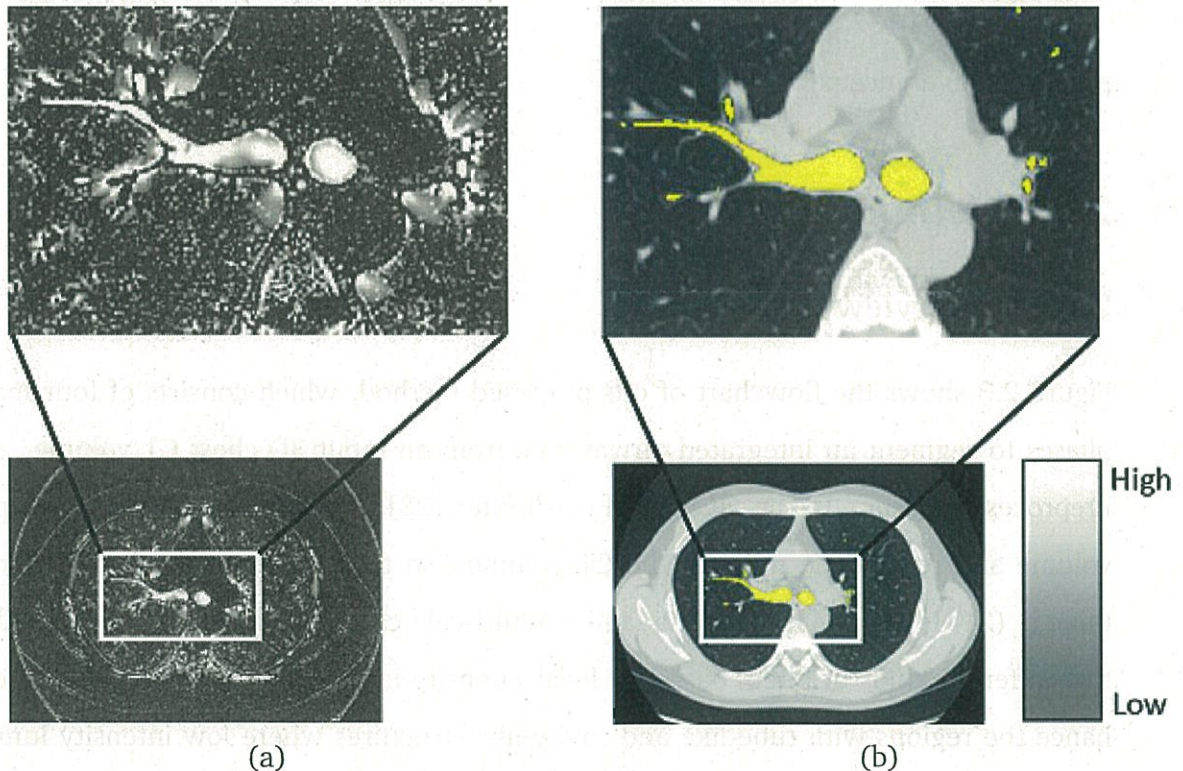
Example results of tube enhancement filter. (a) Output of tube enhancement filter. Thinner bronchial regions are obviously enhanced. (b) Bronchus region manually painted overlapping a CT axial slice.
